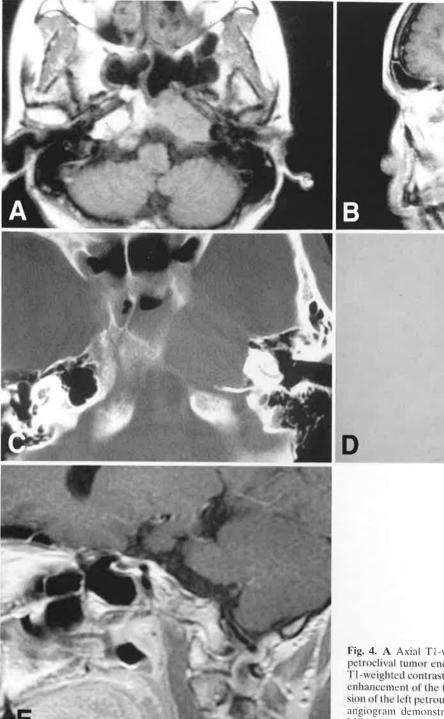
A Axial T1-weighted MR imaging of case 2 exhibits a left petroclival tumor encasing the left internal carotid artery. B Sagittal T1-weighted contrast-enhanced MR imaging reveals a homogeneous enhancement of the tumor. C Bone-window CT scanning shows erosion of the left petrous apex and clivus. D Anterior view of left carotid angiogram demonstrates the tumor shadow. E Contrast-enhanced MR imaging 30 months after operation demonstrates successful tumor control
